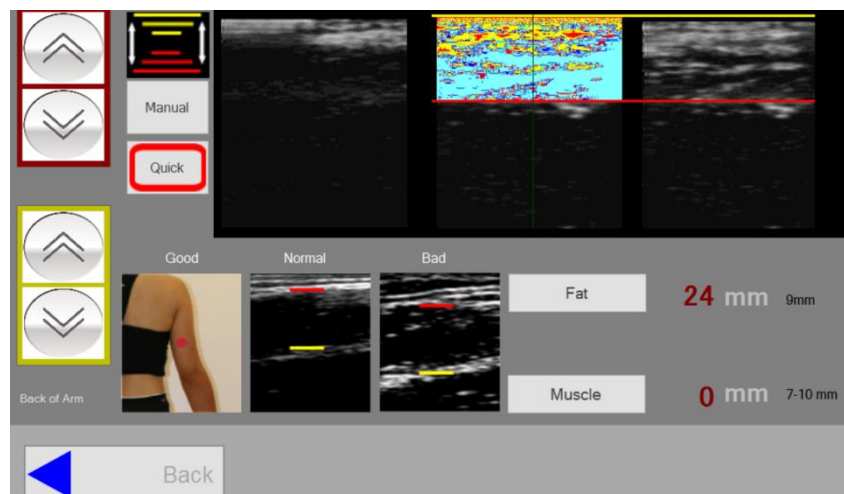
Print screen of automatic ultrasound subcutaneous fat thickness measurement.
